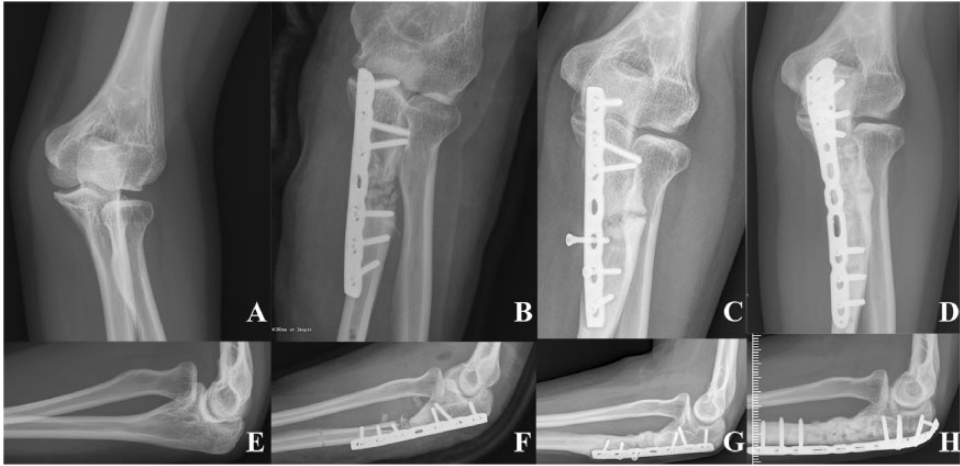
A 19-year-old man had a Bado type I missed Monteggia fracture that was noted on preoperative radiographs (a, e). Open reduction and ulnar angulation osteotomy with plate fixation was initially performed (b, f). Nonunion was demonstrated 4 years after the first surgery (c, g). Eventually, the osteotomy was healed via revision surgery using an autogenous bone graft (d, h).
